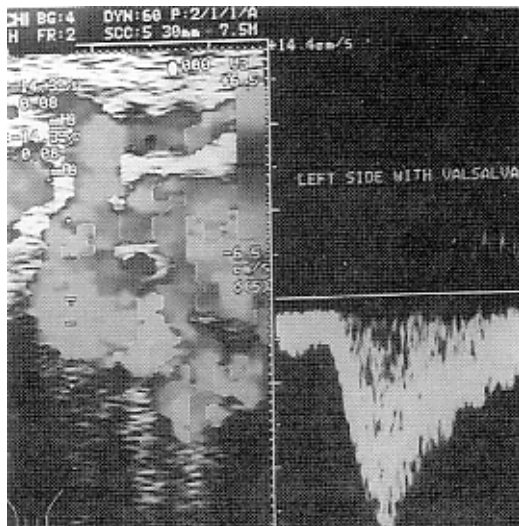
Doppler examination of varicocele, score of 9 before surgery.
